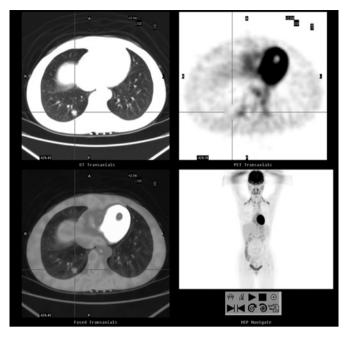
FDG-PET/CT imaging shows a well-defined nodule with low FDG uptake. FDG-PET/CT, F-fluorodeoxyglucose positron emission tomography/computed tomography.
